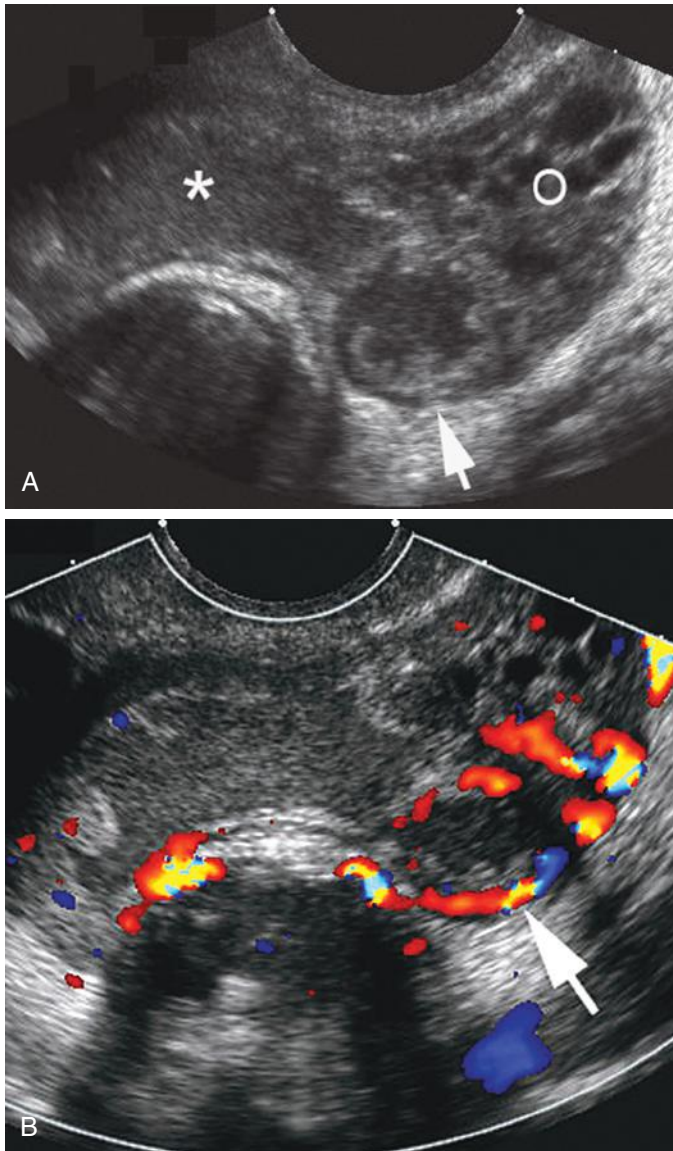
Pyosalpinx in a sexually active 18-year-old girl with gonococcal infection. A, Transvaginal ultrasound image demonstrates a thick-walled fallopian tube containing echogenic material and redundant nodular echogenic endothelial surface (*arrow*) consistent with chronic inflammation, adjacent to the normal left ovary (O). Echogenic fluid is identified within the pelvis (*asterisk*). B, Transvaginal color Doppler ultrasound image reveals hyperemia of the wall of the left fallopian tube (*arrow*). See Video 34-5.
